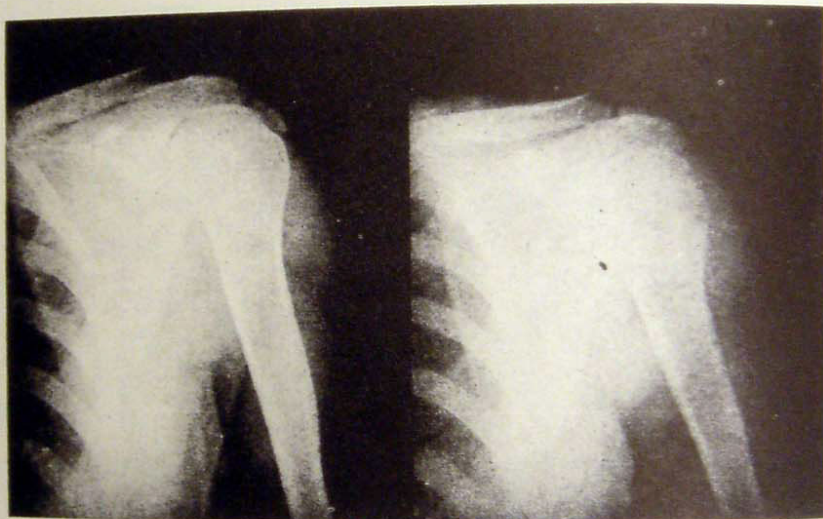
X-rays of shoulder; chronic subdeltoid with calcareous deposit before and after ultrasonic radiation.
